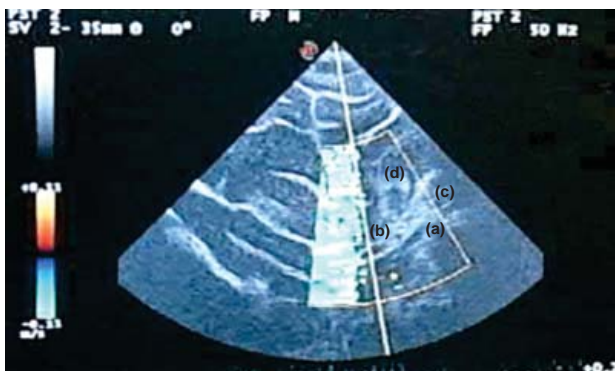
Interoperative neurosonography prior to dural opening showing the carotid artery (b) and the site of origin of the aneurysm in the bifurcation of the middle cerebral artery (a) and the anterior cerebral artery (c). Detail showing orientation of the dome of the aneurysm in the anterior cerebral artery, as well as the presence of the clot in the dome at the point where the rupture probably occurred (d).
